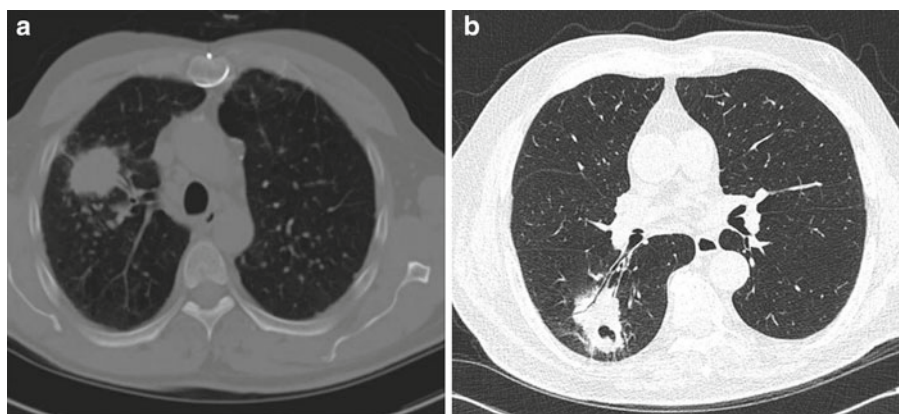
Chest CT showing (a) Type I tumor–bronchus relationship, (b) Type II tumor–bronchus relationship
